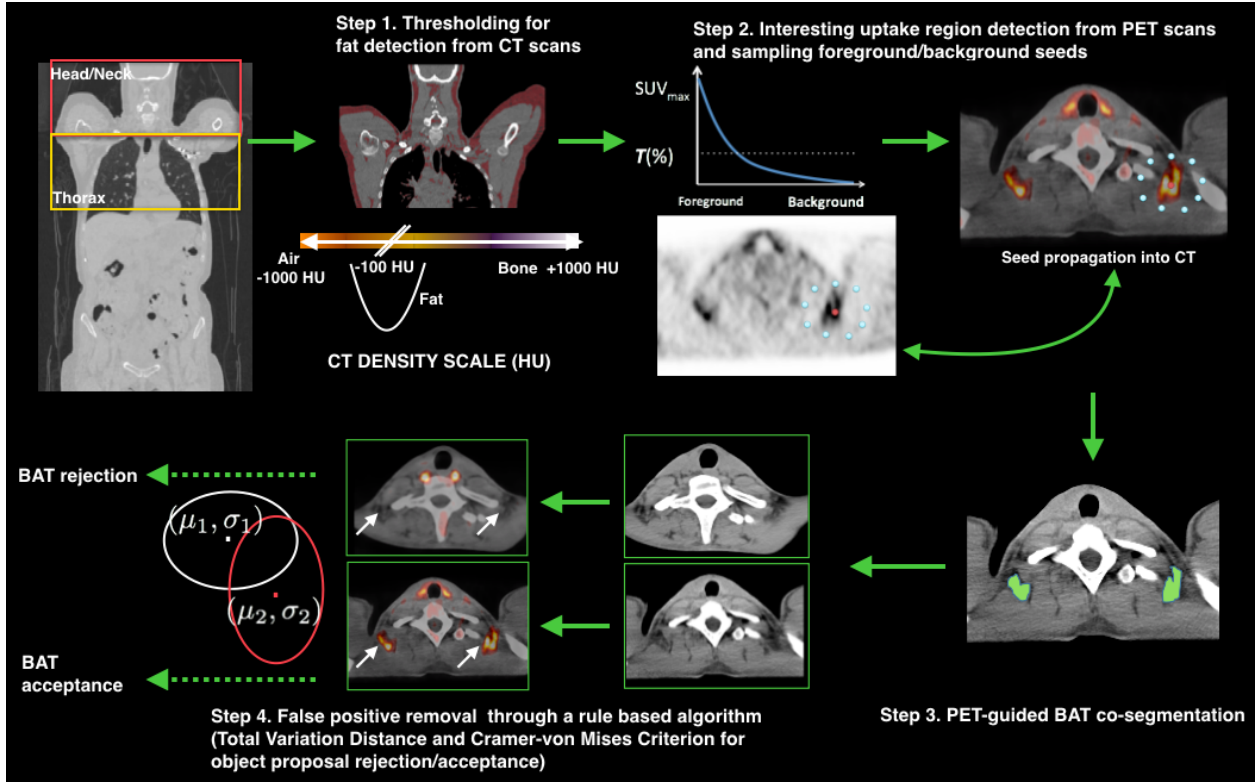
An overview of the proposed Brown Adipose Tissue (BAT) detection and segmentation system. Given the head-neck and thorax regions, adipose tissue is identified using CT thresholding intervals (Step 1). Using the corresponding PET scans, segmentation seeds are sampled in accordance with high uptake regions (Step 2). PET-CT co-segmentation is performed using Random Walk (Step 3) followed by false positive removal (Step 4) using Total Variation and Cramér-von Mises distances.
